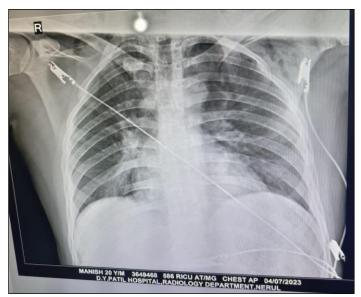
Chest radiography showed clearing of infiltrates
